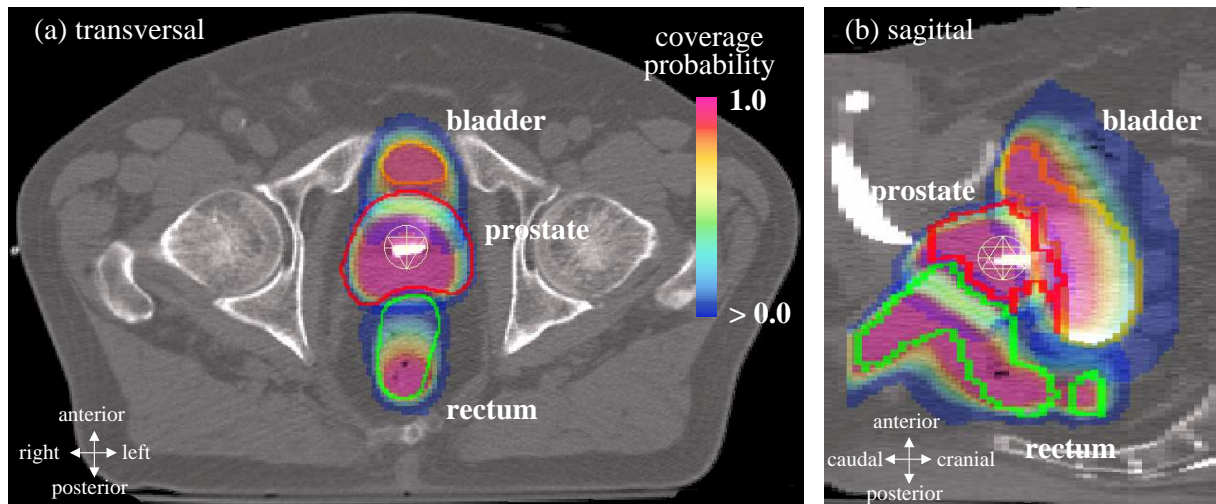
(a) transversal and (b) sagittal view of the pelvic region in the planning CT scan for the example patient. The color-overlay shows the coverage probability distributions of internal organ motion for prostate, bladder and rectum as calculated with a PCA-model of the three organs. The contours depict the positions and shapes of the organs as seen in the planning CT.
